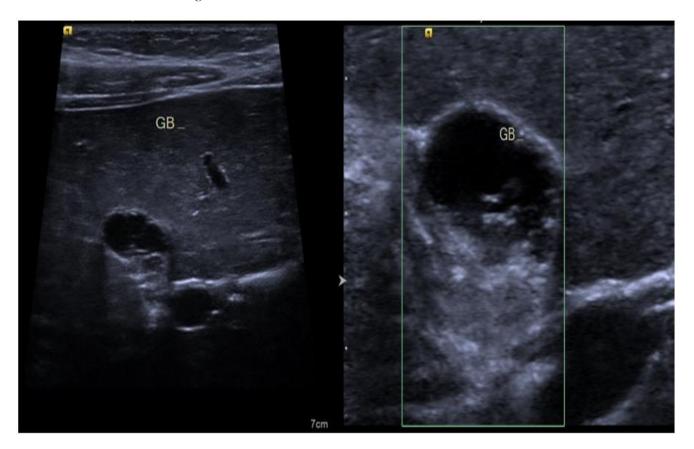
Abdomen Ultrasound Imaging
